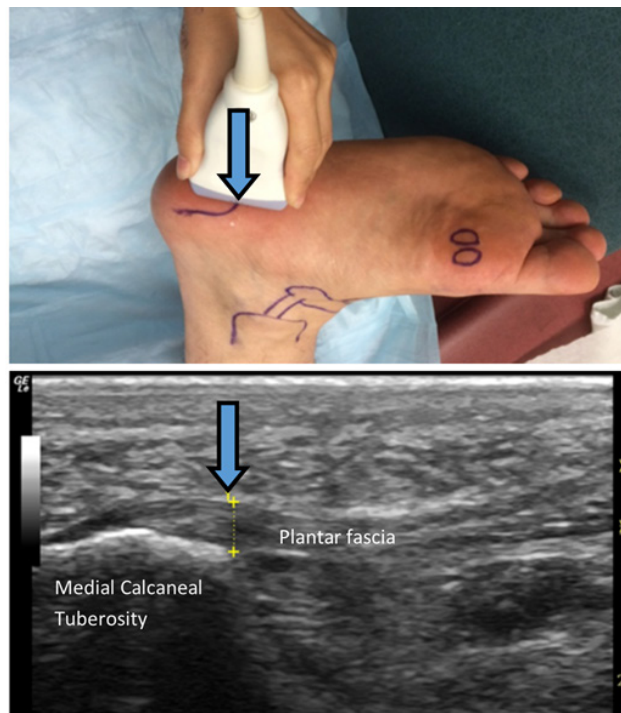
Bedside ultrasound of the plantar heel revealed the insertion of plantar fascia on the medial calcaneal tubercle. The arrow indicates the area the resident correctly marked as the insertion site of plantar fascia (the exact location of the plantar fasciitis)
